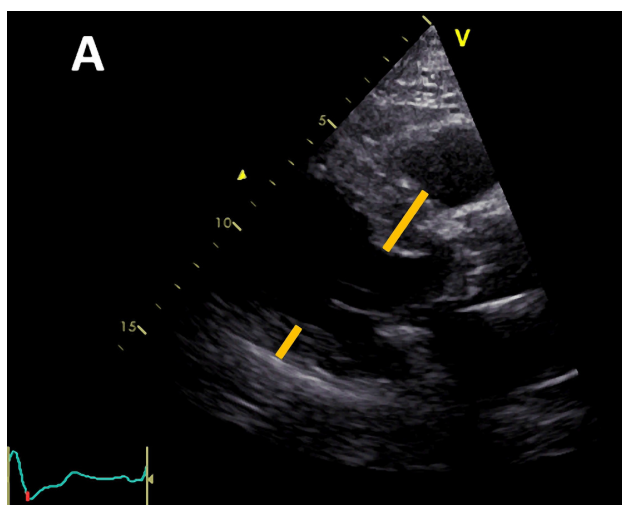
Echocardiography - parasternal long axis view. Left ventricular (LV) hypertrophy without LV enlargement.
